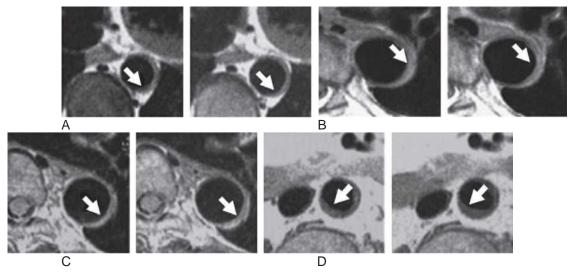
MRI at baseline and after 1 year of atorvastatin treatment. In A, a thoracic aortic plaque showed 28% vessel wall area reduction with a 20-mg dose of atorvastatin. In B, a thoracic aortic plaque showed 15% progression with a 5-mg dose. In C, a thoracic aortic plaque showed 15% progression with a 5-mg dose. In D, an abdominal plaque showed 9% progression despite a 20-mg dose. (Modified from Yonemura A, Momiyama Y, Fayad ZA, et al: Effect of lipid lowering therapy with atorvastatin on atherosclerotic aortic plaques detected by noninvasive MRI. J Am Coll Cardiol 45:733, 2005.)
